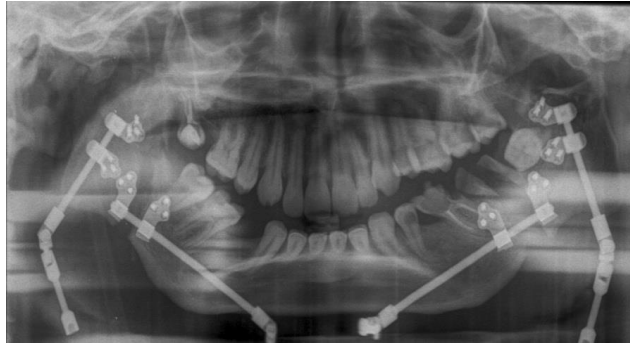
panoramic radiograph after insertion of distraction device
